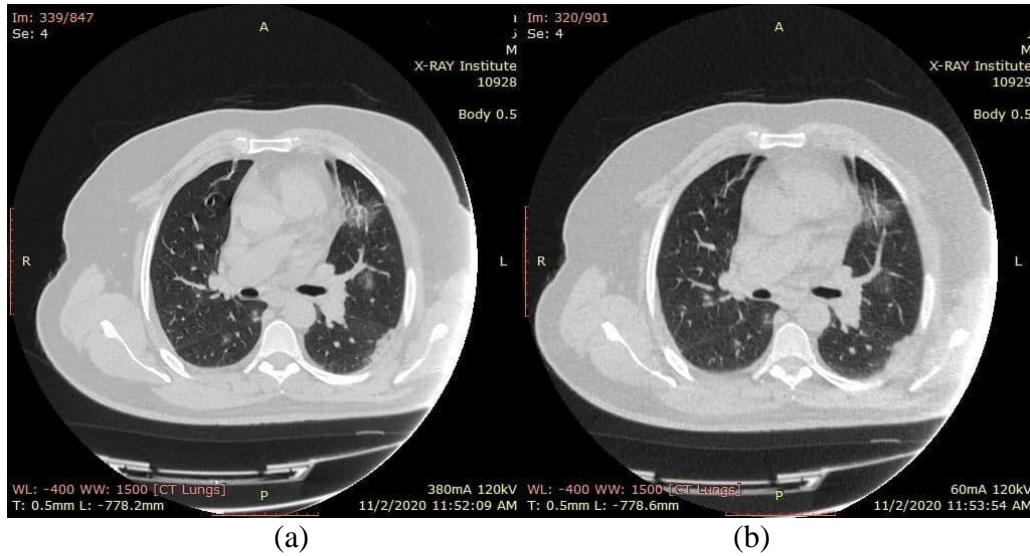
Chest computed tomography scans of 54-year-old male that had COVID -19; (a) Standard-dose, (b) low-dose images.
